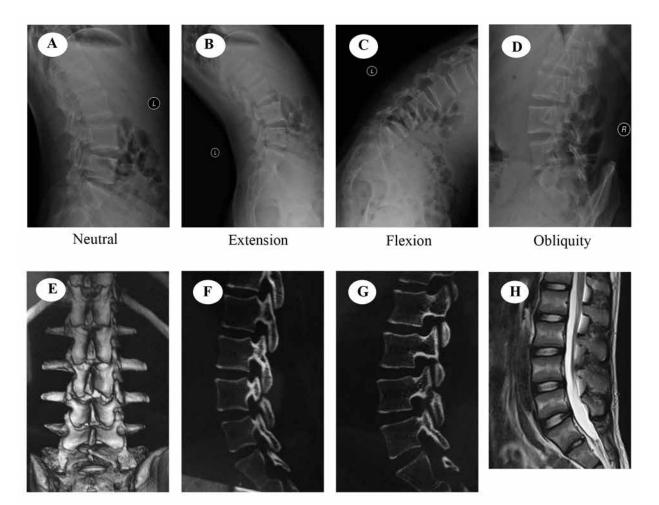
The imaging for the patient at the first presentation. Neutral lateral is not standard (A). The spondylolysis can be noted at the L3 vertebral level (B, D). No instability with the dynamic motion can be observed (B, C). CT scans were taken and the lumbar spondylolysis at L3 was further identified (E). Right sagittal and left sagittal indicate spondylolysis (F, G). MRI indicated no compression of the intracanal neural tissue and lumbar disc degeneration (H).
